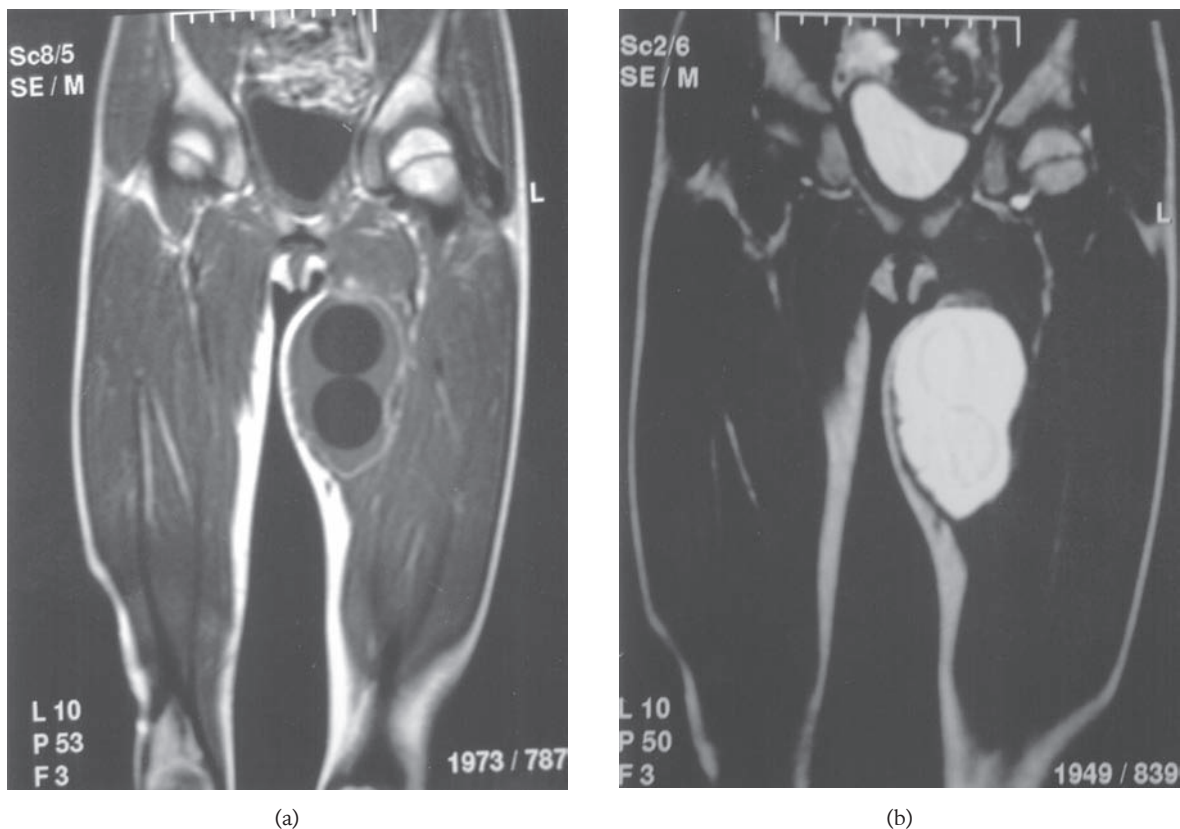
T1-weighted (a) and T2-weighted (b) coronal magnetic resonance images show a well-defined cyst in the medial thigh containing daughter cysts.
